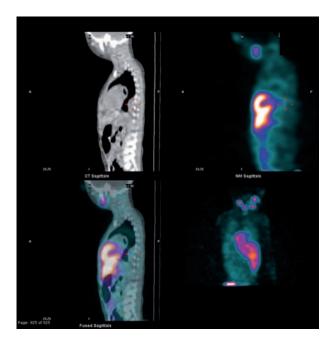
MIBG and SPET scintigraphy: slight accumulation of radio-drug in mediastinal mass
